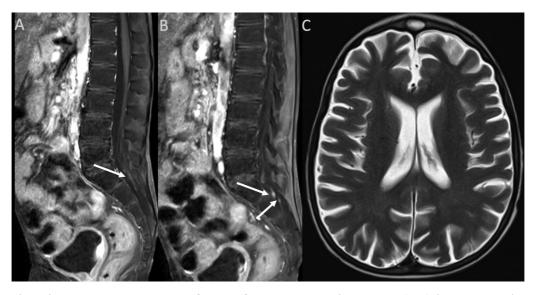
Brain and spinal magnetic resonance imaging of case 2. After contrast, sagittal T1W images (A, B) show contrast enhancement in the sacral nerve roots (arrows). Axial T2W image (C) shows cerebral atrophy.
